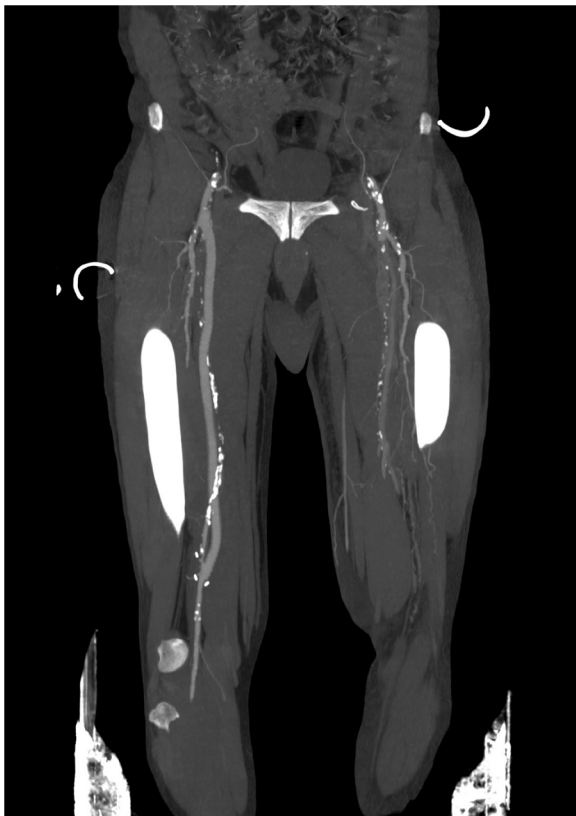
Postoperative CT maximum intensity projection showing maintained patency of the femoro-popliteal bypass.
